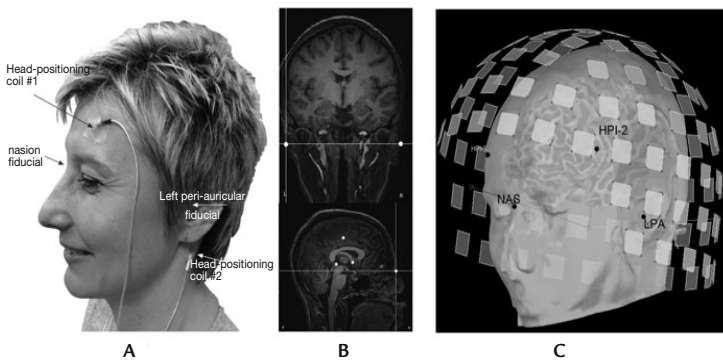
(A–C) Multimodal MEG-MRI geometrical registration. (A) 3 to 5 head-positioning indicators are taped onto the subject's scalp. Their positions, together with 3 additional anatomical fiducials (nasion, left and right periauricular points) are digitized by a magnetic pen digitizer. (B) The anatomical fiducials need to be detected and marked (white dots) in the subject's anatomical MRI volume data, together with 3 optional, additional points defining the anterior and posterior commissures and the interhemispheric space, for the definition of Talairach coordinates. (C) These anatomical landmarks henceforth define a geometrical referential in which the MEG sensor locations and the surface envelopes of the head tissues (e.g., the scalp and brain surface, segmented from the MRI volume) are coregistered. MEG sensors are shown as squares positioned about the head. The anatomical fiducials (*NAS*, *LPA*) and locations of the head position indicators (*HPI*) are marked with black dots
